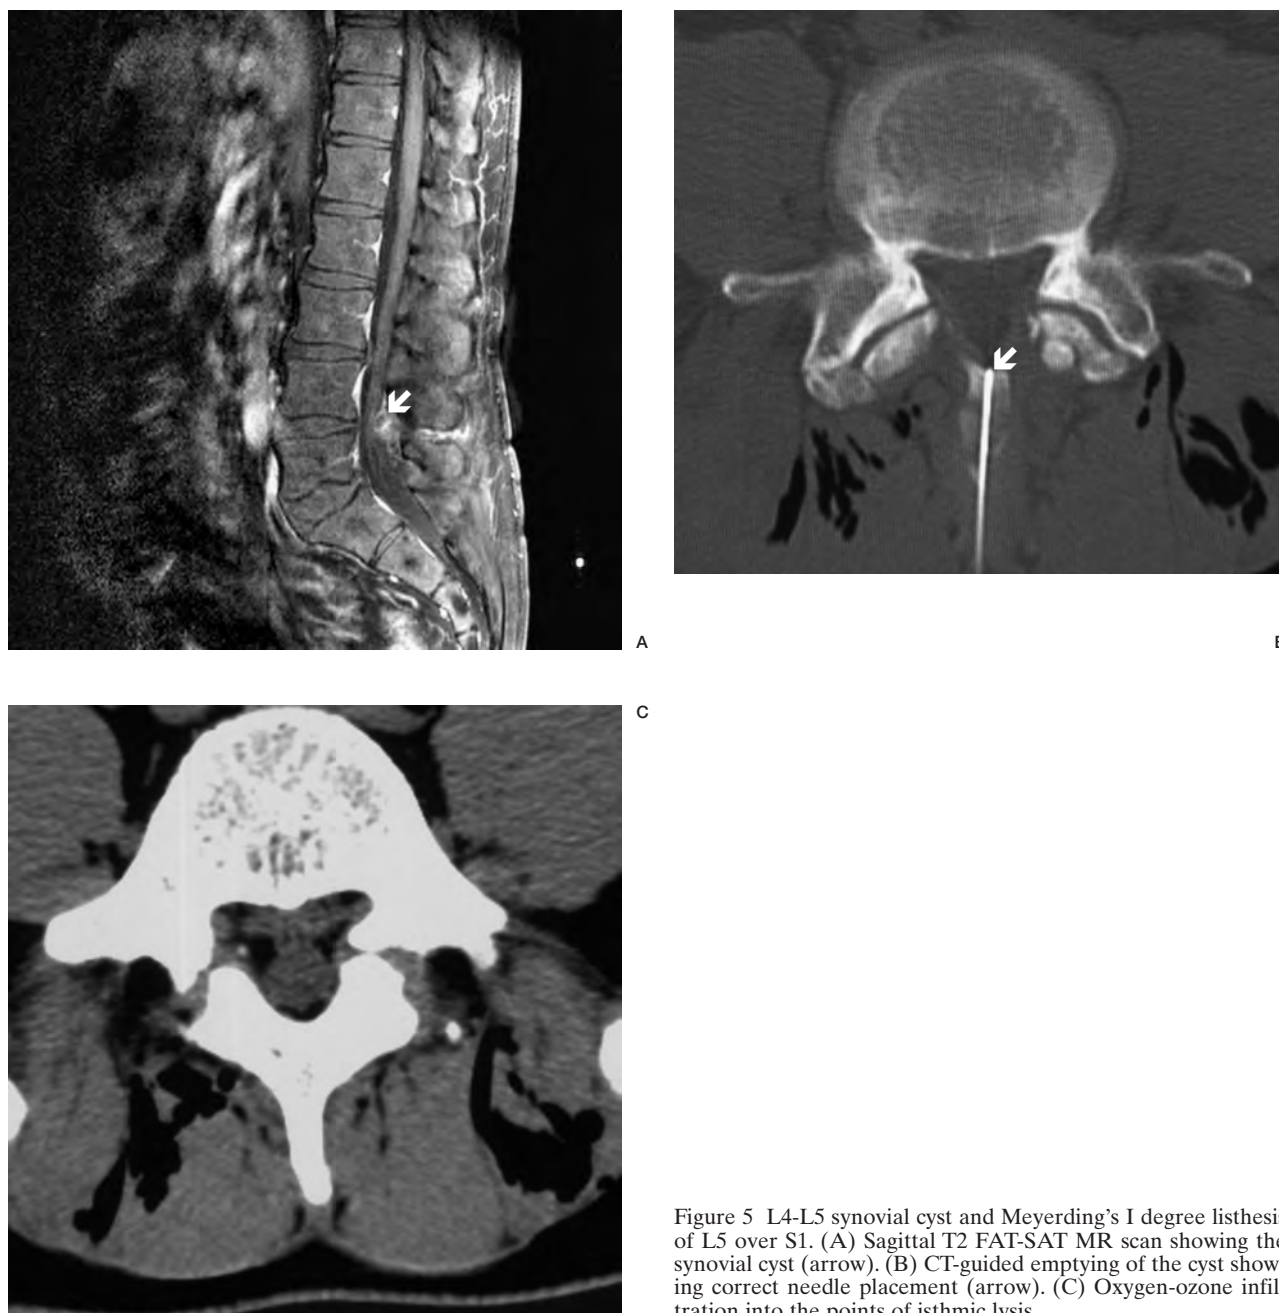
L4-L5 synovial cyst and Meyerding's I degree listhesis of L5 over S1. (A) Sagittal T2 FAT-SAT MR scan showing the synovial cyst (arrow). (B) CT-guided emptying of the cyst showing correct needle placement (arrow). (C) Oxygen-ozone infiltration into the points of isthmic lysis.
